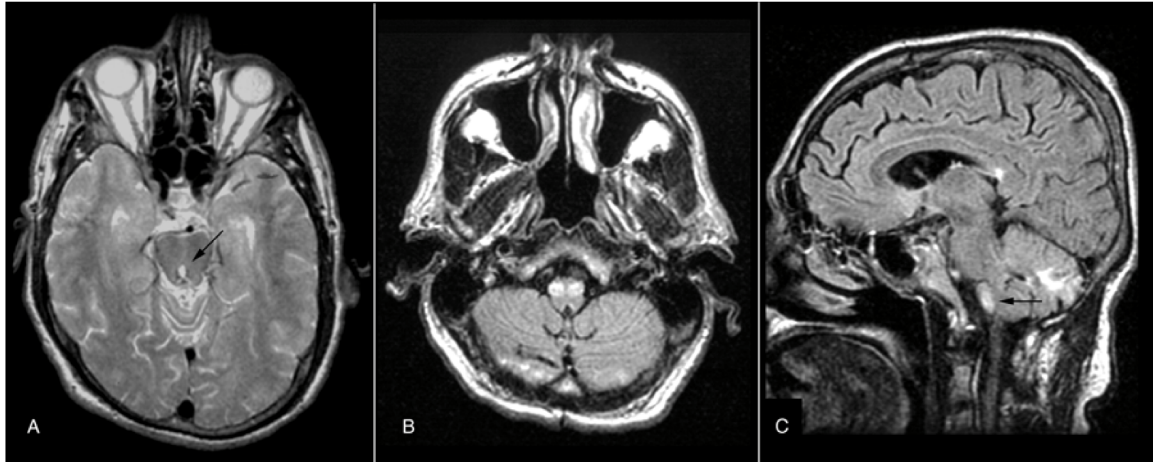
MR imaging of patient 3. (A) Axial, T2-weighted MR image obtained 6 months postoperatively demonstrates the unremarkable postoperative changes in the brainstem. The resection cavity is located in the midline at the pontomesencephalic junction (arrow). (B) Postoperative axial FLAIR MR image shows increased signal intensity within the lateral aspect of both sides of the medulla with enlargement of both inferior olivary nuclei; bilateral HOD. (C) Postoperative sagittal FLAIR MR image demonstrates the increased signal intensity and enlargement of the inferior olive within the ventral medulla (arrow).
